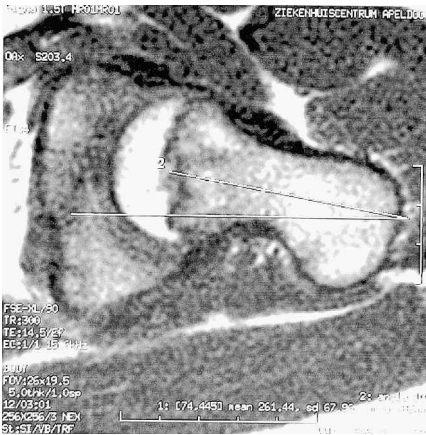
MRI measurement of the alpha angle of the left femoral neck (10°).
